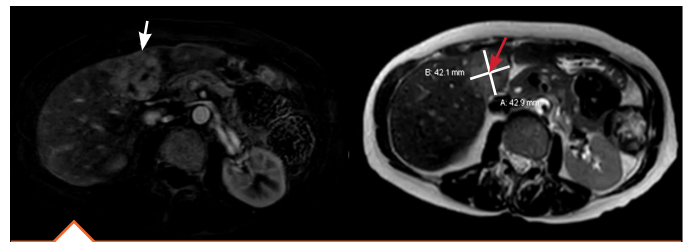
Contrast enhanced MRI demonstrates a 4.3 x 4.2 cm mass within segment 4 of the left hepatic lobe. The mass demonstrates contrast enhancement with focal areas of central necrosis.
